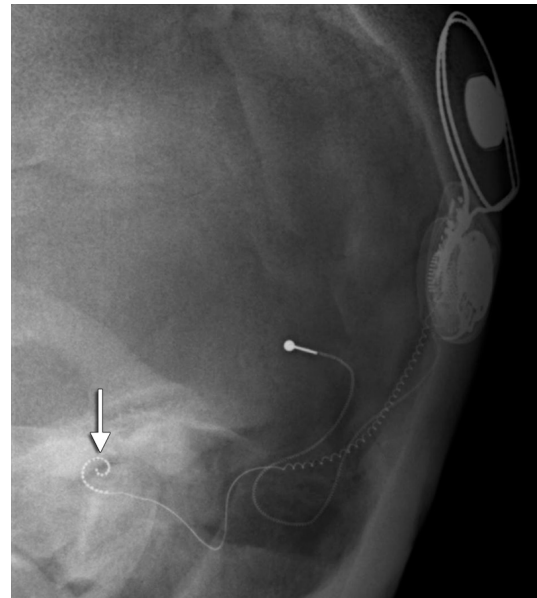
Radiograph of cochlear implant. Normal Stenvers radiograph status post multichannel intracochlear electrode placement showing a normal curvature (arrow) of the electrode array within the cochlea and an intact wire leading from the array to the receiver-stimulator.
